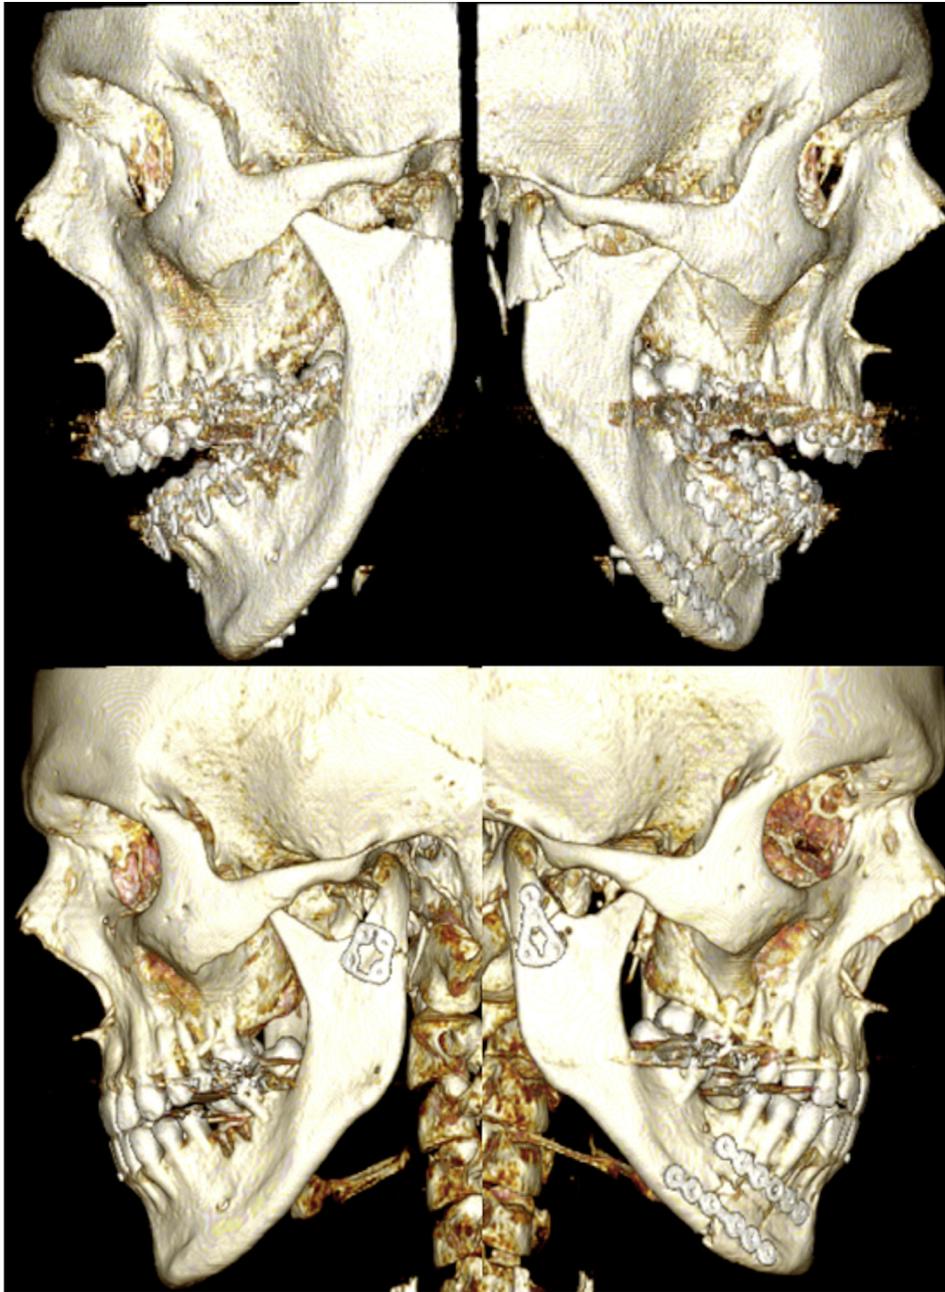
Patient 6. Preoperative three-dimensional computed tomographic image showing anterior open bite, bilateral subcondylar fractures with lateral (right) and medial (left) displacement, and a right body fracture treated by another surgeon. Postoperative three-dimensional computed tomographic image showing adequate reduction of the bilateral subcondylar fractures; the left fracture was reduced and fixed via a retromandibular approach after a failed reduction attempt using an intraoral approach.
